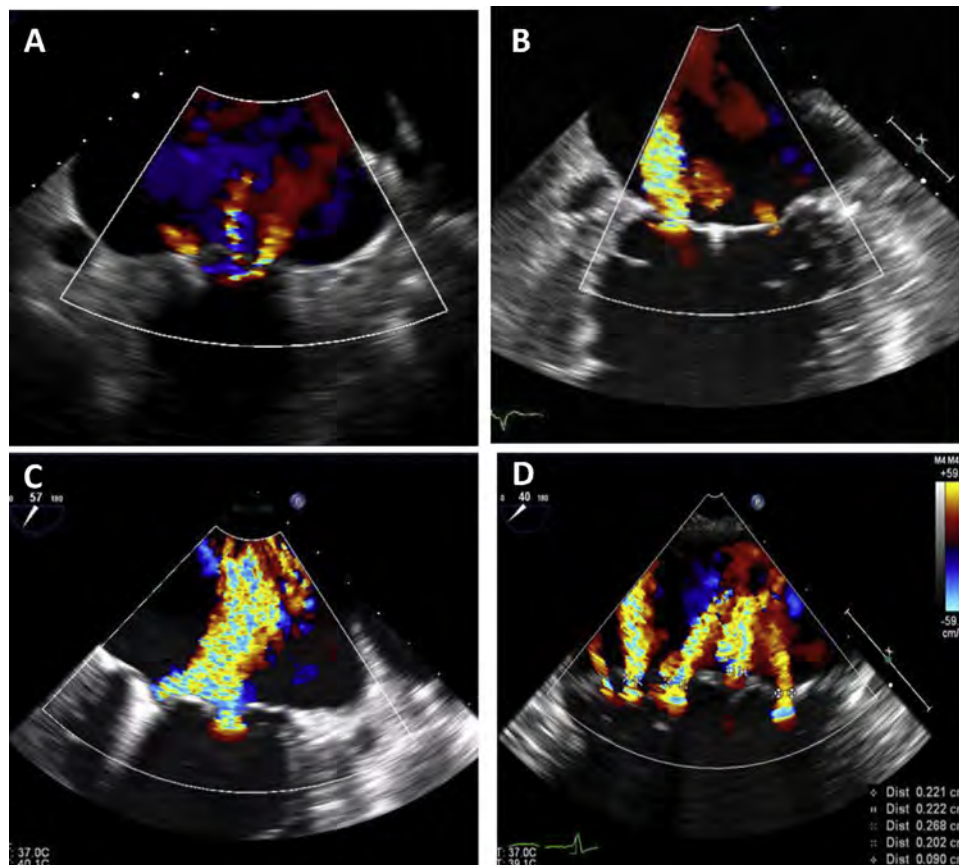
Challenges of multiple MR jets after edge-to-edge mitral valve repair. Transesophageal echocardiographic images from a mid-esophageal level. (A) Three separate, small jets are seen. (B) A large jet with a wide orifice is seen medial to the device with a very small jet laterally. (C) Two separate large jets, crisscrossing with a confluence close to the valve. (D) Five different residual jets of variable severity seen after deployment of a single clip.
